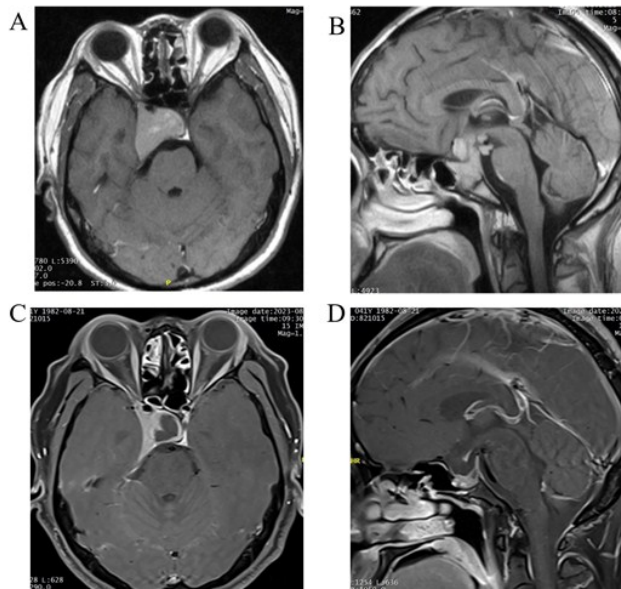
MRI contrast images of the patient before and after gamma knife treatment (A-B: MRI images of the patient before treatment; C-D: MRI images of the patient after treatment)
